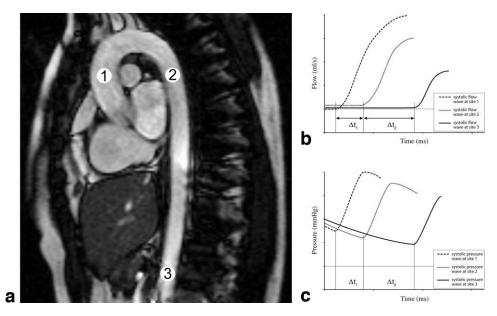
Analysis of pulse wave velocity with MRI and invasive pressure measurements. a: An oblique sagittal scout covering the full course of the aorta, indicating the sites for the through-plane velocity-encoded PWV<sub>MRI</sub> assessments and the invasive pressure measurements for PWV<sub>INV</sub>: the ascending aorta (1), the proximal descending aorta just distal to the aortic arch (2), and the most distal level of the abdominal aorta depicted in the oblique sagittal scout (3). Determination of the onset of the three systolic flow waves for PWV<sub>MRI</sub> at the measurement sites are depicted in b, while determination of the onset of the three systolic pressure waves for PWV<sub>INV</sub> at the measurement sites are depicted in c. The distance between these sites and the transit time ( $\Delta t_1$  and  $\Delta t_2$ ) between the individual onsets of the systolic flow waves (B,C) determine the PWV.
